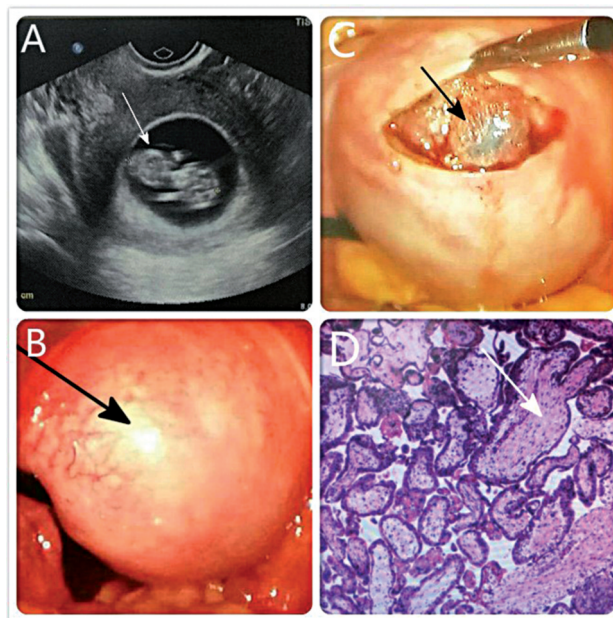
(A) Preoperative transvaginal ultrasound scan reveals a 10-week normal fetus which was described to be highly localized in the uterus. (B) Laparoscopic view shows that the uterine size is larger with an unruptured mass which protrudes from the fundal myometrium and is distinct from both fallopian tubes. (C) After incision of the serous layer, the fetus and clear amniotic fluid outflow are observed. (D) Pathological diagnosis showed the presence of chorionic villi in the intramural pregnancy.
